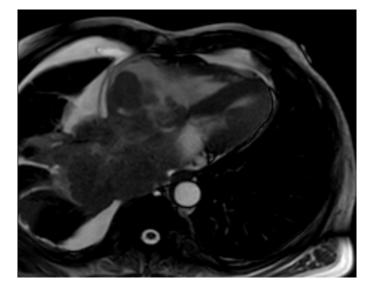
On cardiac MRI a giant mass with late contrast enhancement and a connection with the lungs was observed spreading from both atria to the heart.
